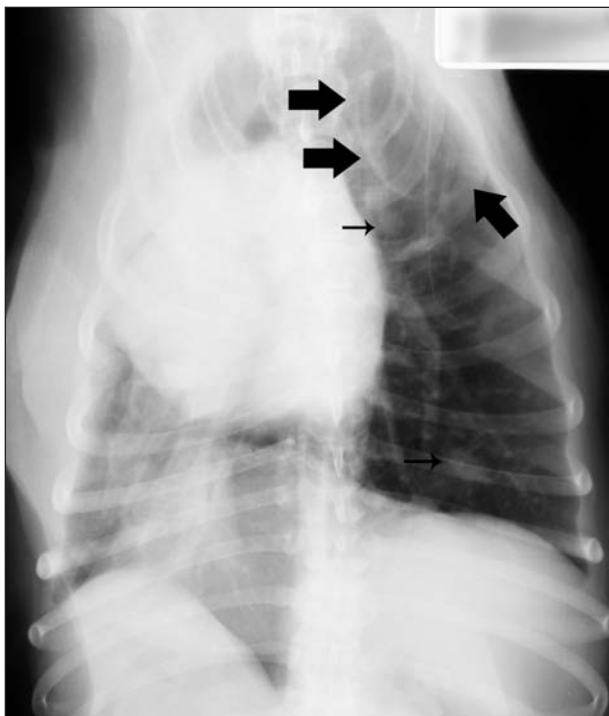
Same ventrodorsal radiographic view as in Figure 1. Notice a large bulla in the left cranial lung lobe (large arrows) and mediastinal shift caused by atelectasis of the right middle lung lobe. The soft tissue mass can be seen along the right lateral wall of the thorax. A diffuse, unstructured interstitial pattern and multiple interstitial nodules (small arrows) of various sizes are seen in the lungs.
